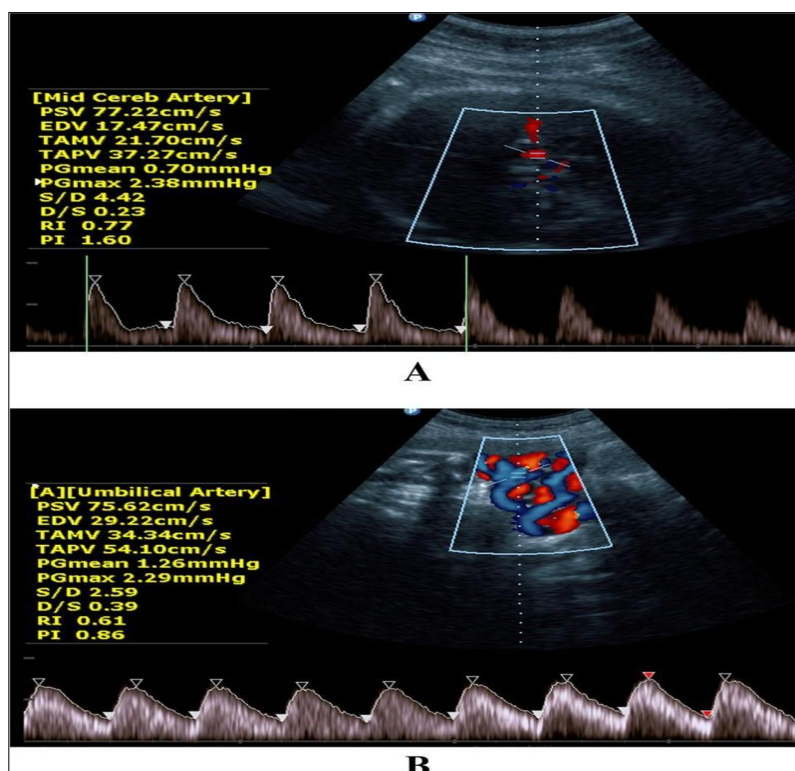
Doppler Ultrasound Waveforms of Mid Cerebral and Umbilical Arteries with Flow Metrics
